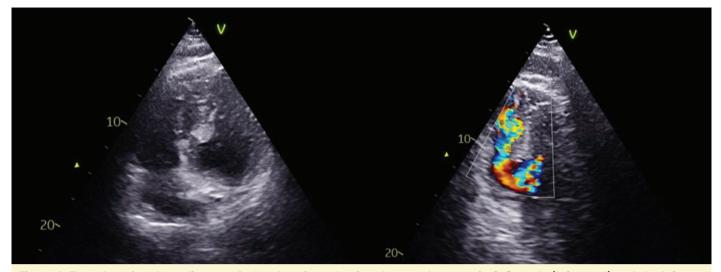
Transthoracic echocardiogram, 4-chamber view, showing the septal rupture in 2-D mode (left panel) and the left-toright shunt with color Doppler (right panel).
